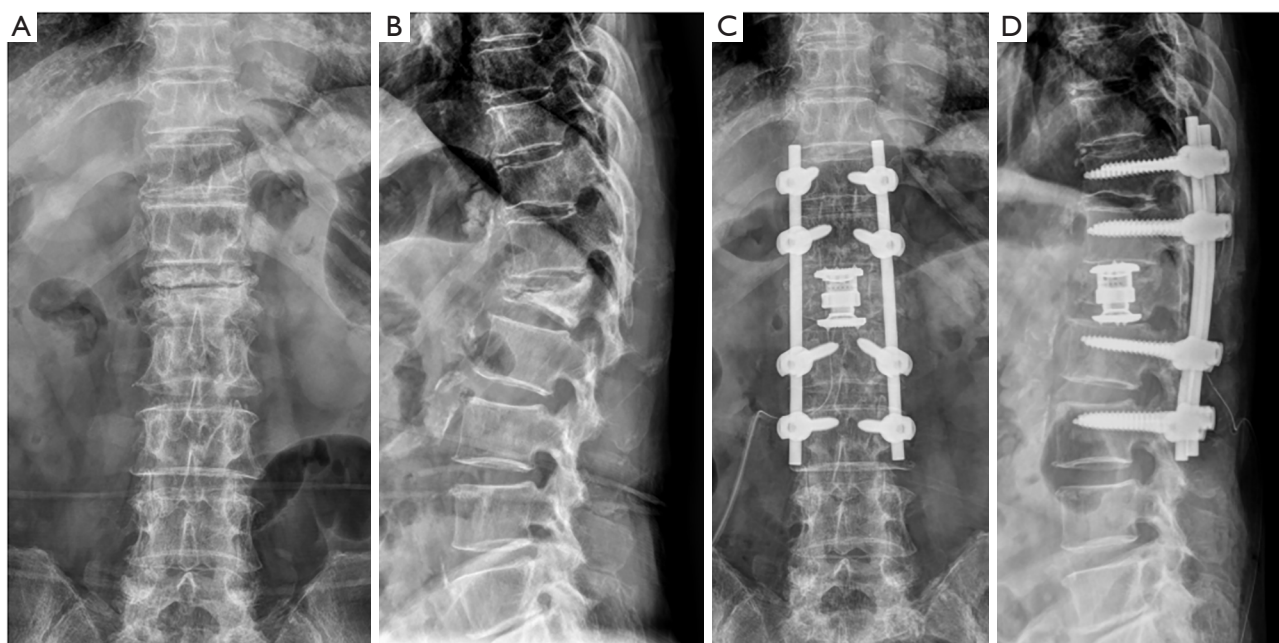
Conventional corpectomy case. A 73-year-old female patient was diagnosed with L1 Kümmell's disease and underwent surgery after 3 months of conservative treatment. Since the bone quality was relatively not poor, corpectomy following metal cage insertion and posterior instrumentation with fusion was performed via a posterior only approach. However, this required relatively long operating time (operating time =210 min) and large amount of blood loss (estimated blood loss =900 cc). (A) Preoperative anteroposterior X-ray demonstrates intravertebral vacuum cleft on the 1st lumbar vertebra. (B) Preoperative lateral X-ray shows L1 vertebral body collapse with segmental kyphosis. (C) Postoperative anteroposterior X-ray. After removing the whole vertebral body of L1 through a posterior approach, anterior support was performed using expandable cage. (D) Postoperative lateral X-ray shows improvement of segmental alignment.
